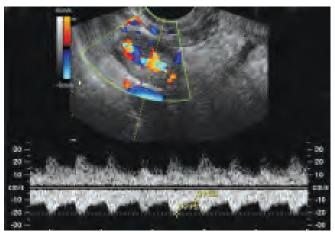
The same patient as in Figure 44.10. Angiogenesis signals typical of corpus luteum formation are easily displayed by color Doppler ultrasound
